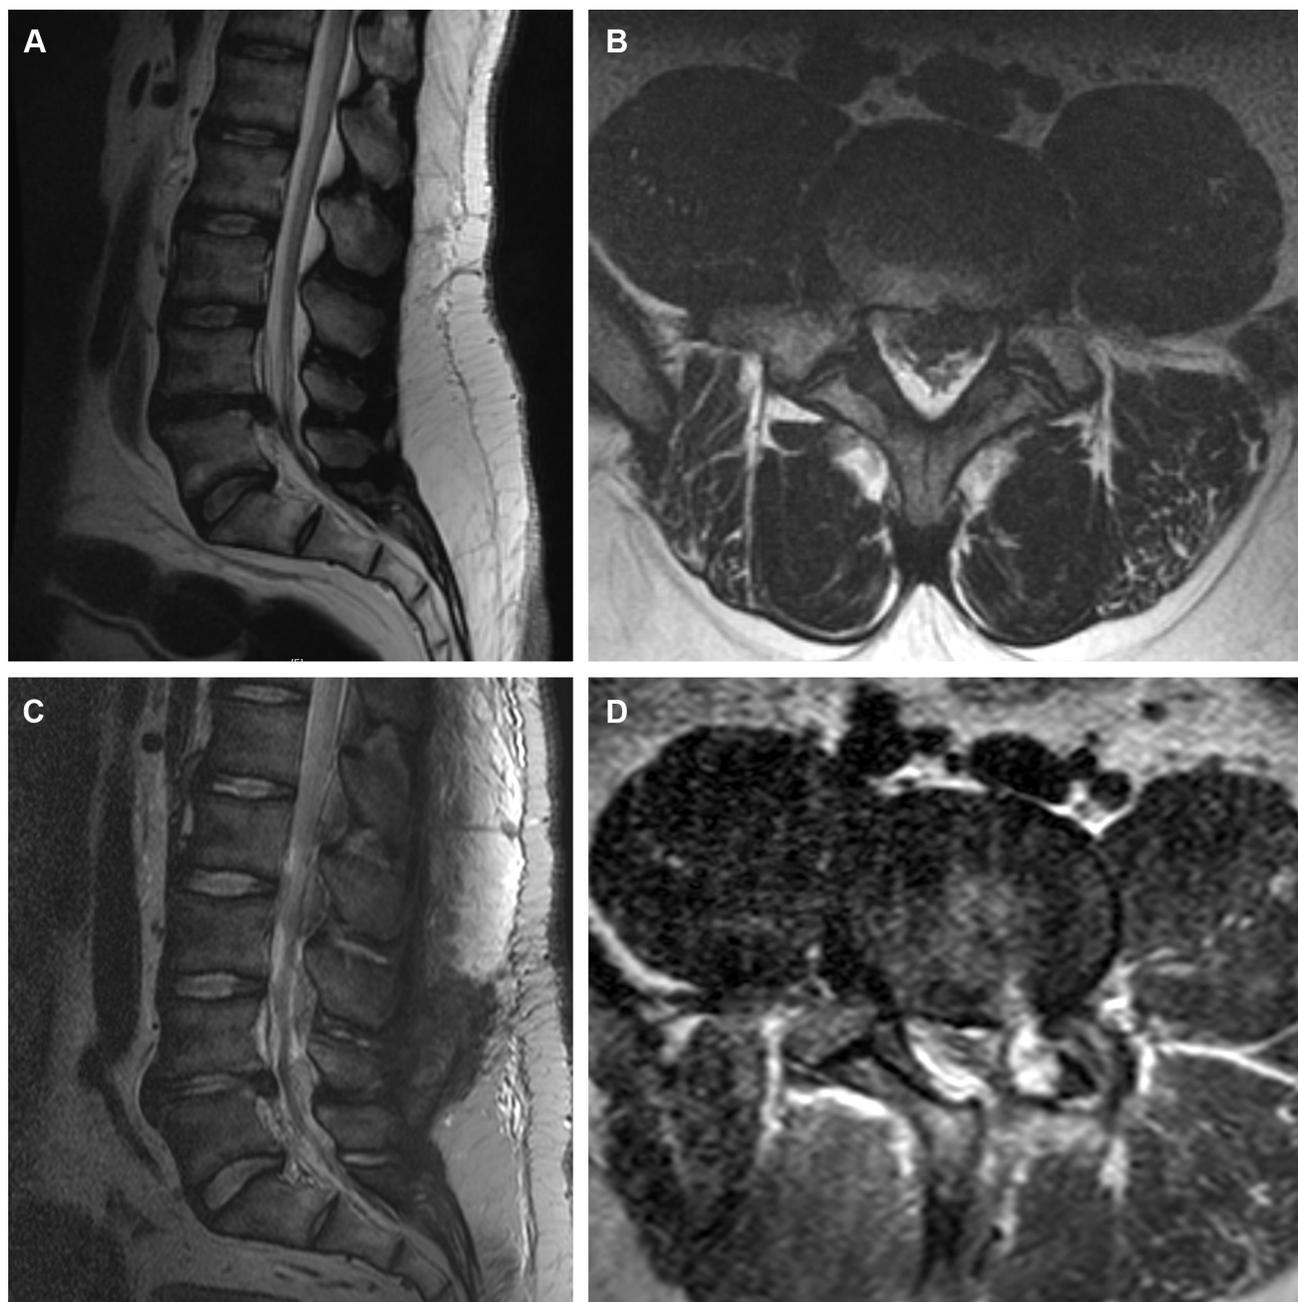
Preoperative sagittal (A) and axial (B) T2-weighted magnetic resonance imaging of the lumbar spine in a 42-year-old man who presented with symptoms of left leg pain, numbness, and mild dorsiflexion weakness showing a disc herniation at the L4-5 level. Following left L4-5
